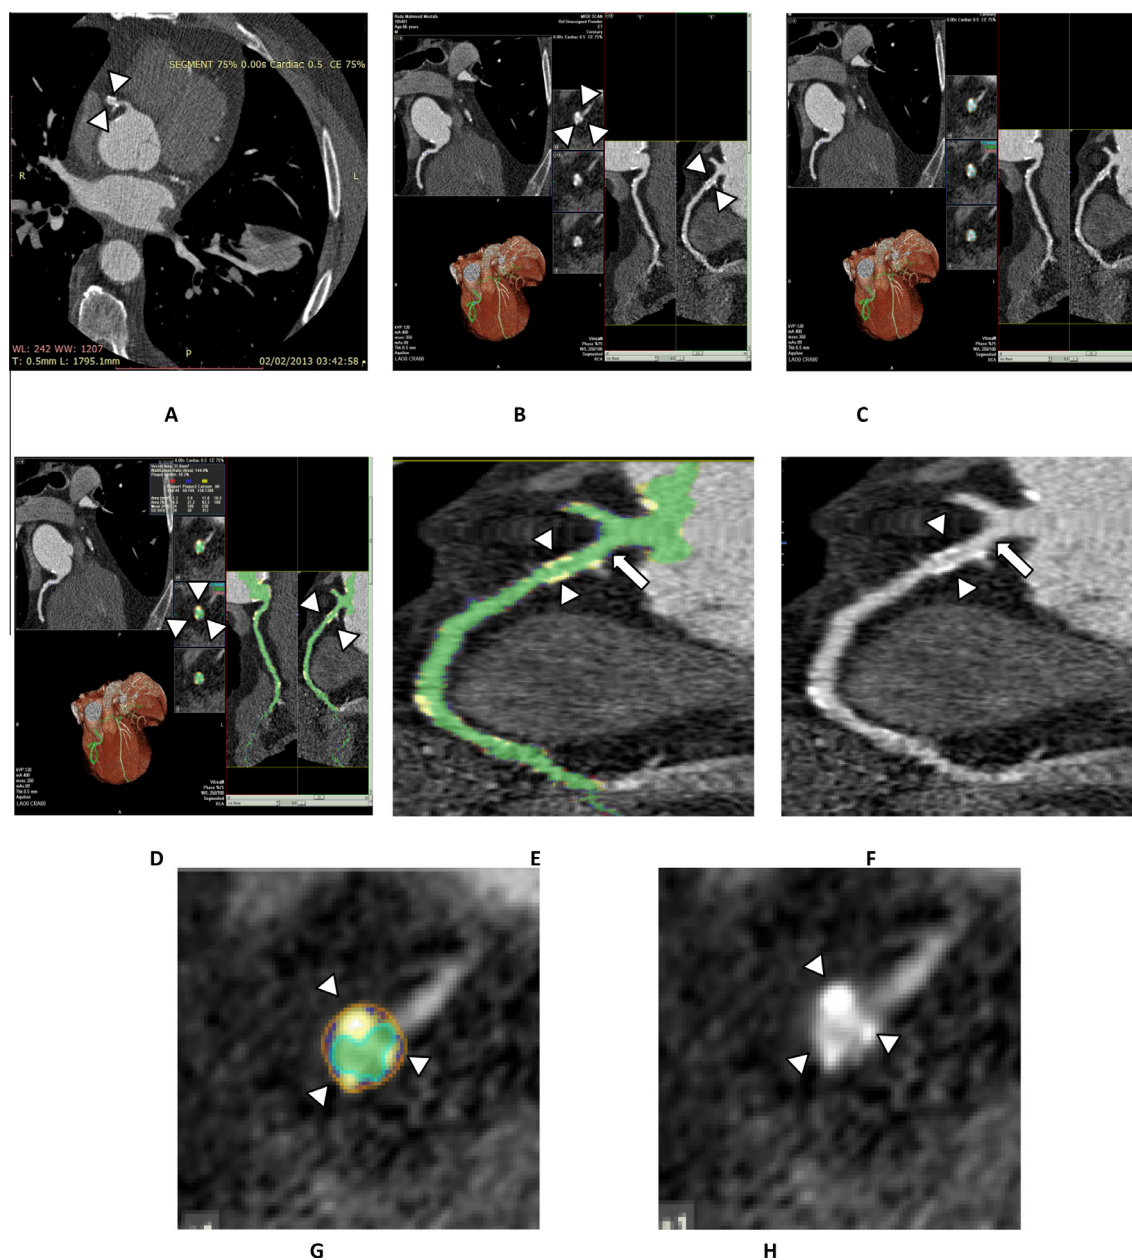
Female patient, 66 years old, with history of controlled hyperlipidemia, came for evaluation of dyspnea. (A) Contrast-enhanced 64 multi-detector rows cross sectional CT image: average caliber dominant RCA is seen normally arising from right coronary sinus giving PDA and PL branches. There are eccentric multiple small predominantly calcific component plaques (white arrowhead) at proximal portion of RCA causing no significant stenosis, the largest measures 2.9 mm in length and 2.6 mm in width. (B and C) Curved multiplanar reformation images of right coronary artery (RCA) show multiple eccentric predominantly calcific plaques causing positive remodeling (white arrowhead). (D) Colored MPR shows positive remodeling at proximal portion of RCA (white arrowhead) (E and F) magnified colored and gray scaled MPR image shows +ve remodeling (as shown by white arrowhead) while the calcified plaques are yellow colored at E. Note the reference segment is free of plaques (white arrow). (G&H) Colored and grey scaled magnified MPR cross sectional images at the site of positive remodeling show the same findings (white arrowhead). The calculated remodeling index = 1.32.
